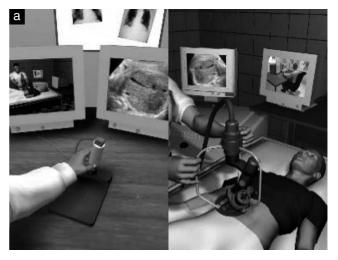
Pictures showing the expert on the left manipulating the fictive expert probe and the patient on the right with the robotic arm positioned on the body by a non-sonographer. (a) When the expert moves his probe to the right, the robotic arm orientates to the right. (b) When the expert moves his probe to the left, the robotic arm orientates to the left.
